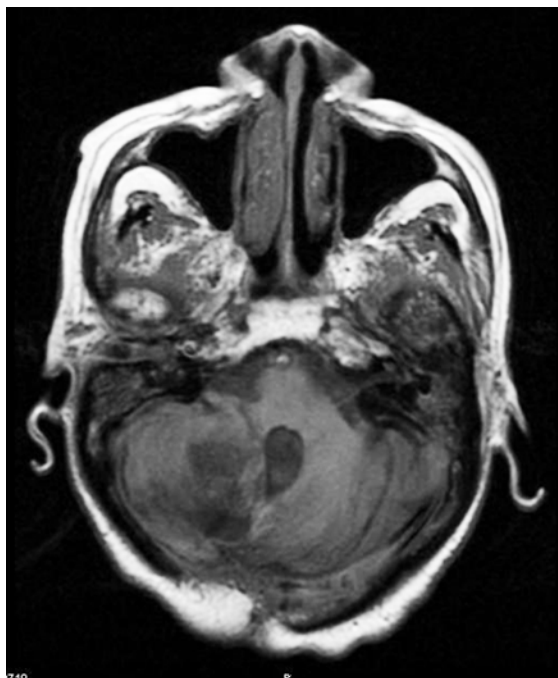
MRI of the brain, which shows a small recurrent tumor
